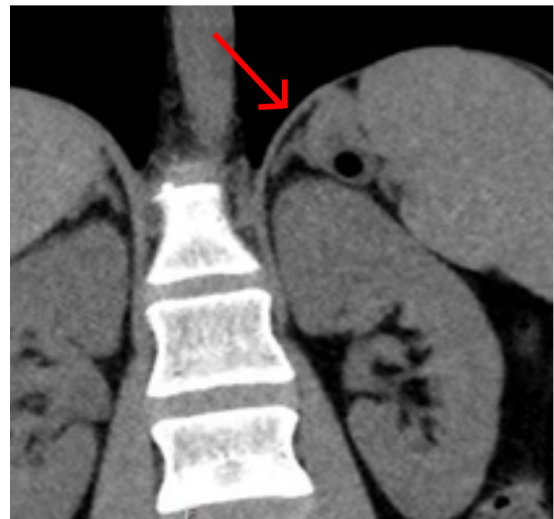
CT-scan-coronal section where saccular image is observed with air density inside. Thin fat line (Arrow) can be seen between the GD and left adrenal gland.
